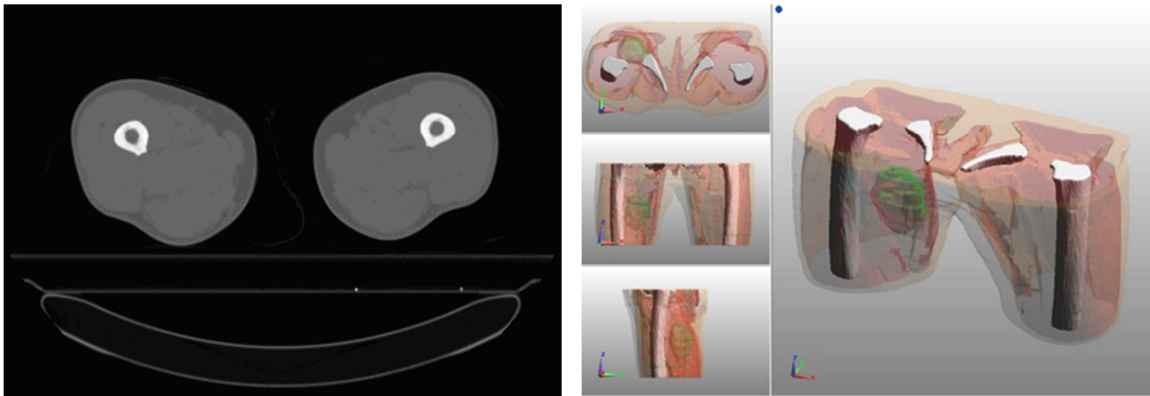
Thigh (a) computed tomography scan [49], (b) 3D anatomical model
